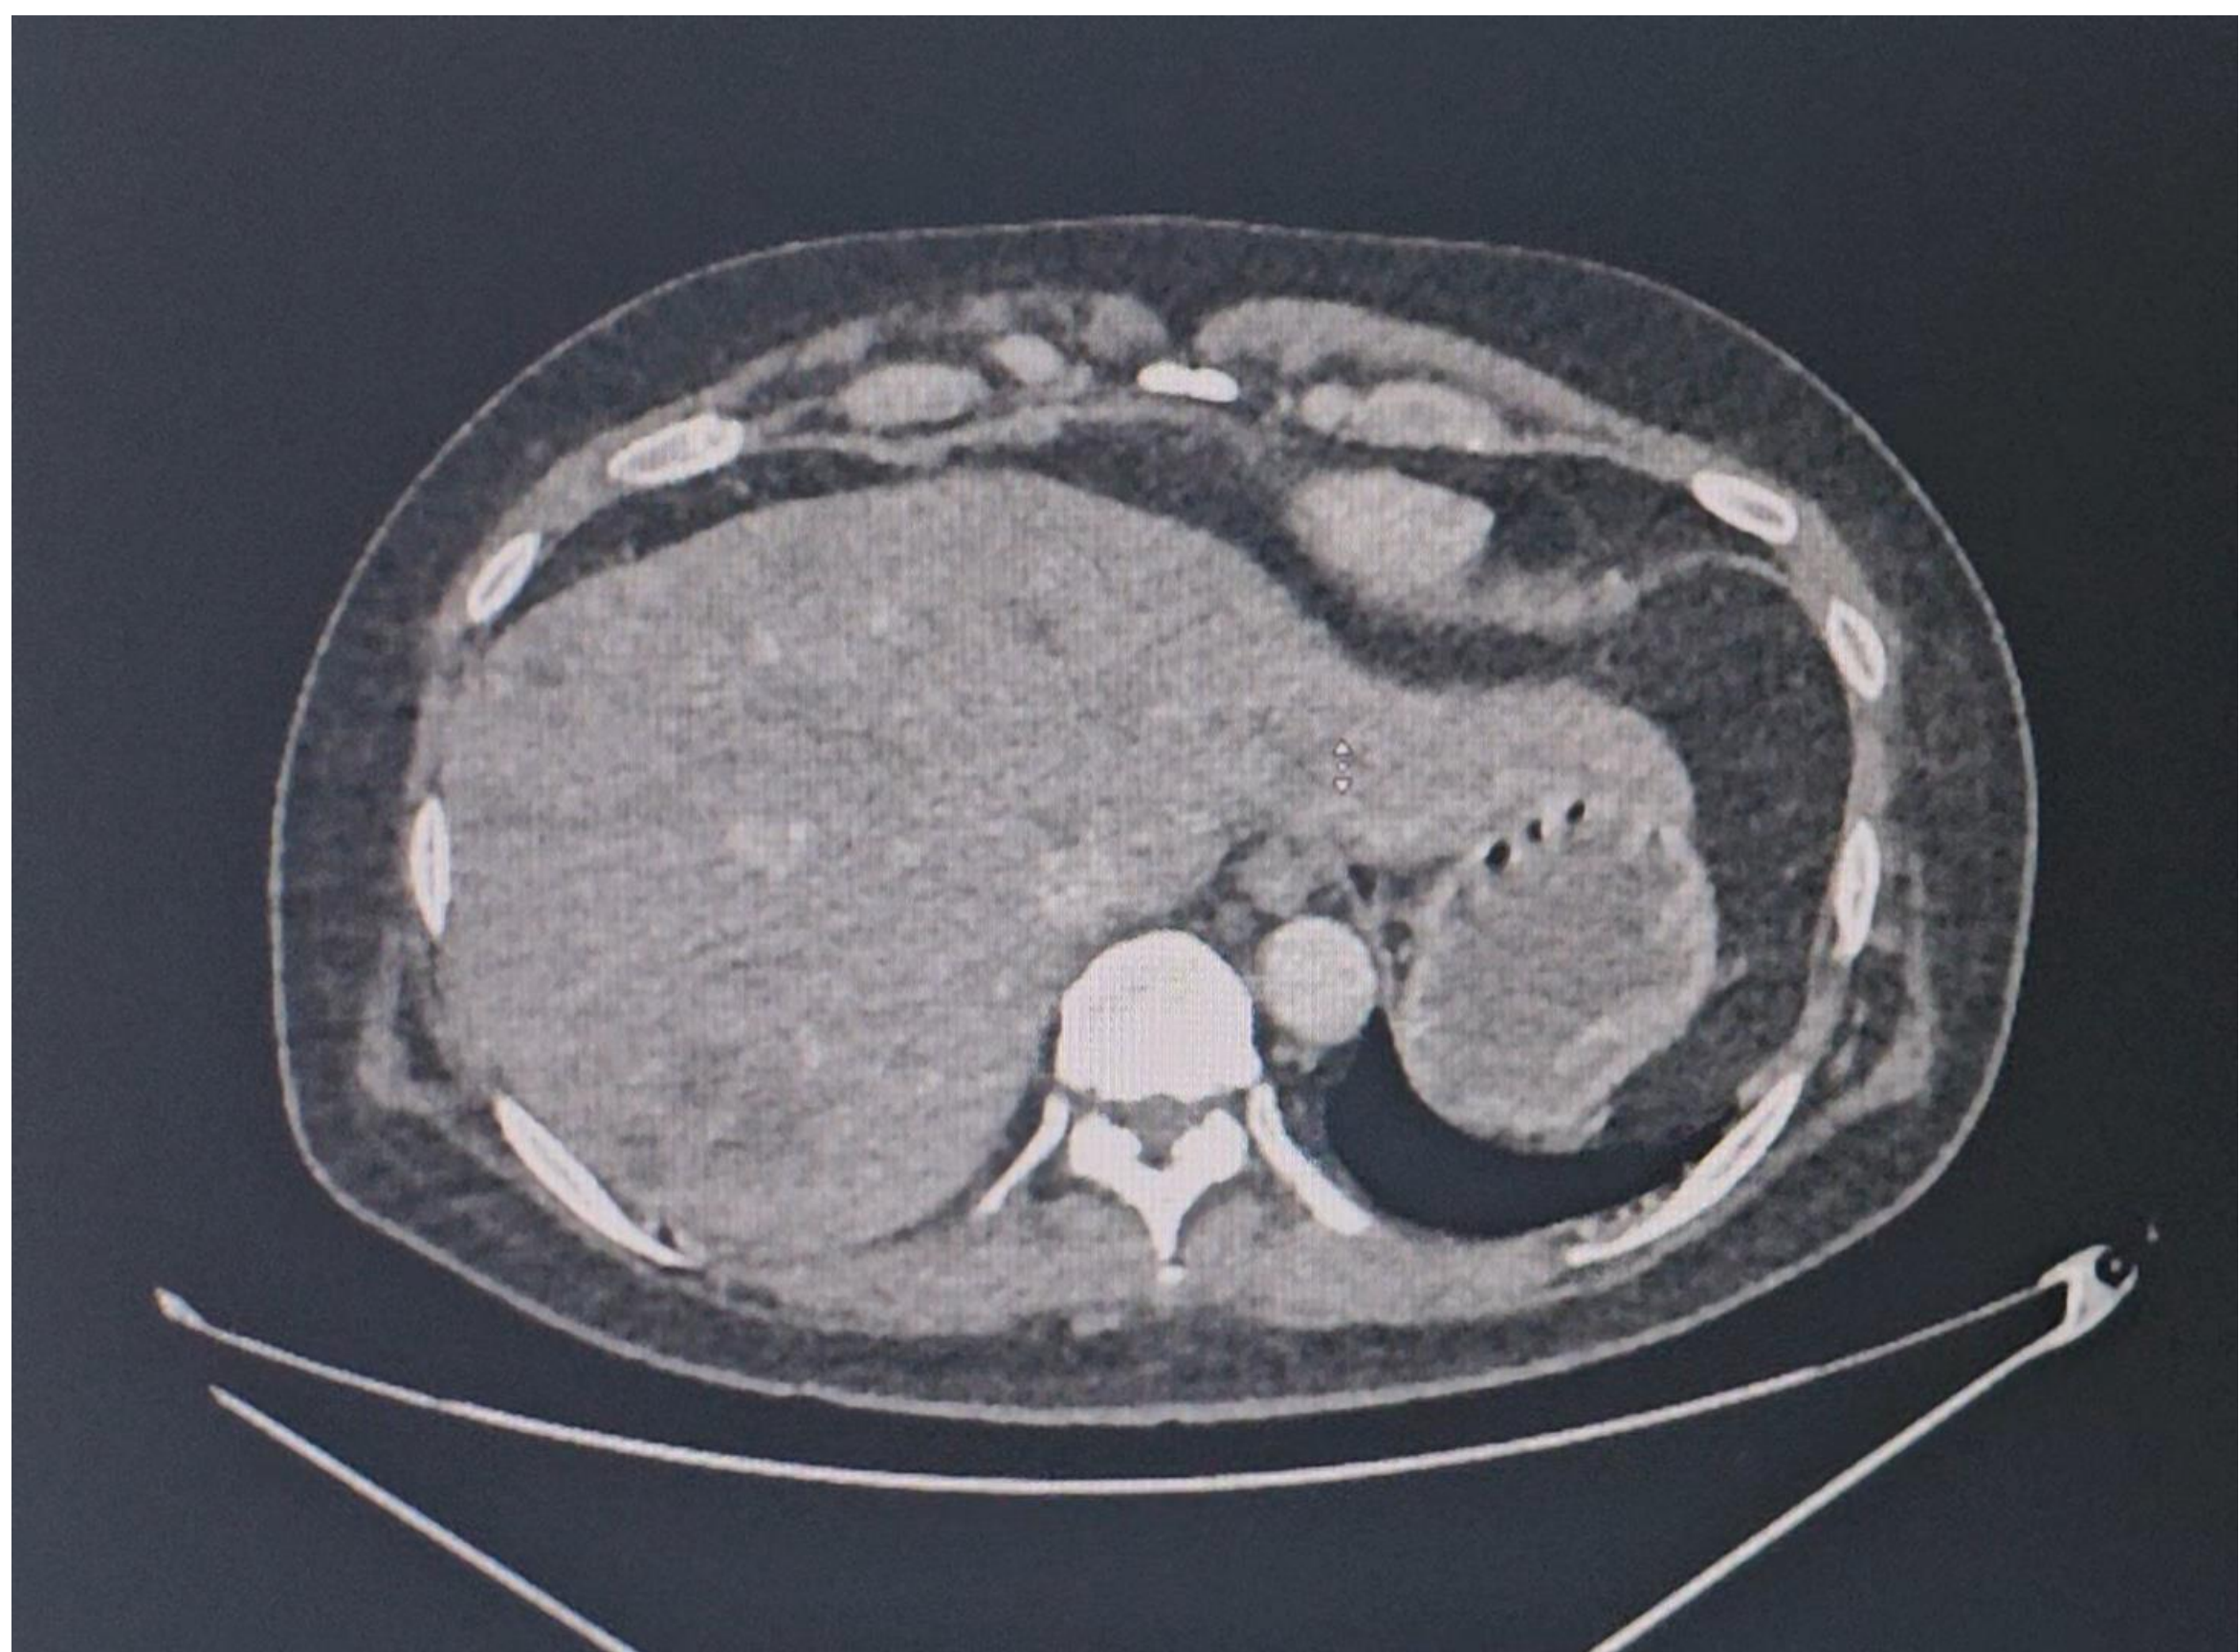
Abdominal CT-scan showed multiple solid nodules occupying the liver, suggesting the possibility of malignancy
